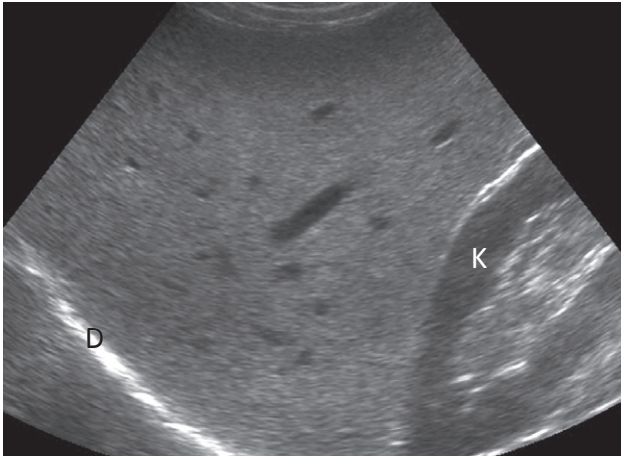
Ultrasound of normal liver. Longitudinal scan showing a uniform echo pattern interspersed with bright echoes of portal triads and echo-free areas of hepatic and portal veins. D, diaphragm; K, right kidney.
